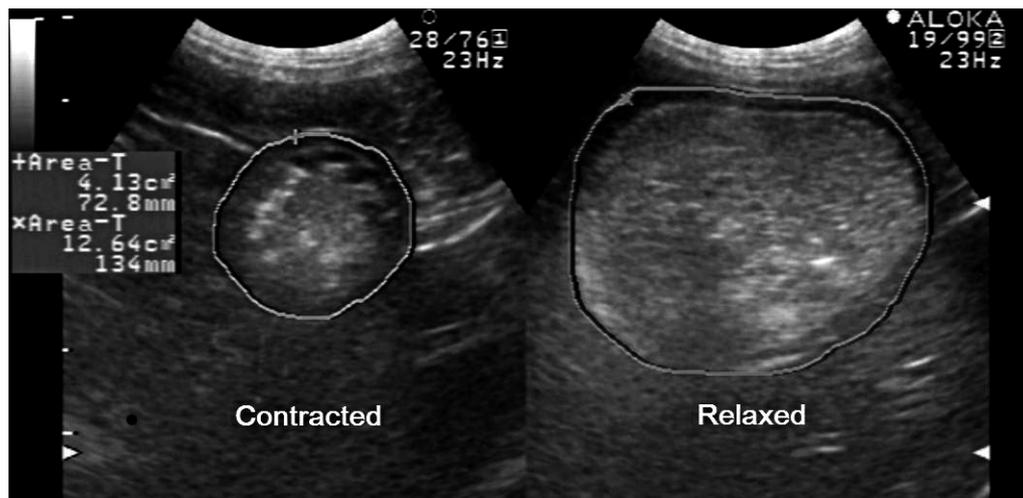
Ultrasonographic scanning of the cross-section of the gastric antrum in a contracted (left) and relaxed (right) phase 30 min after having given the test meal.
